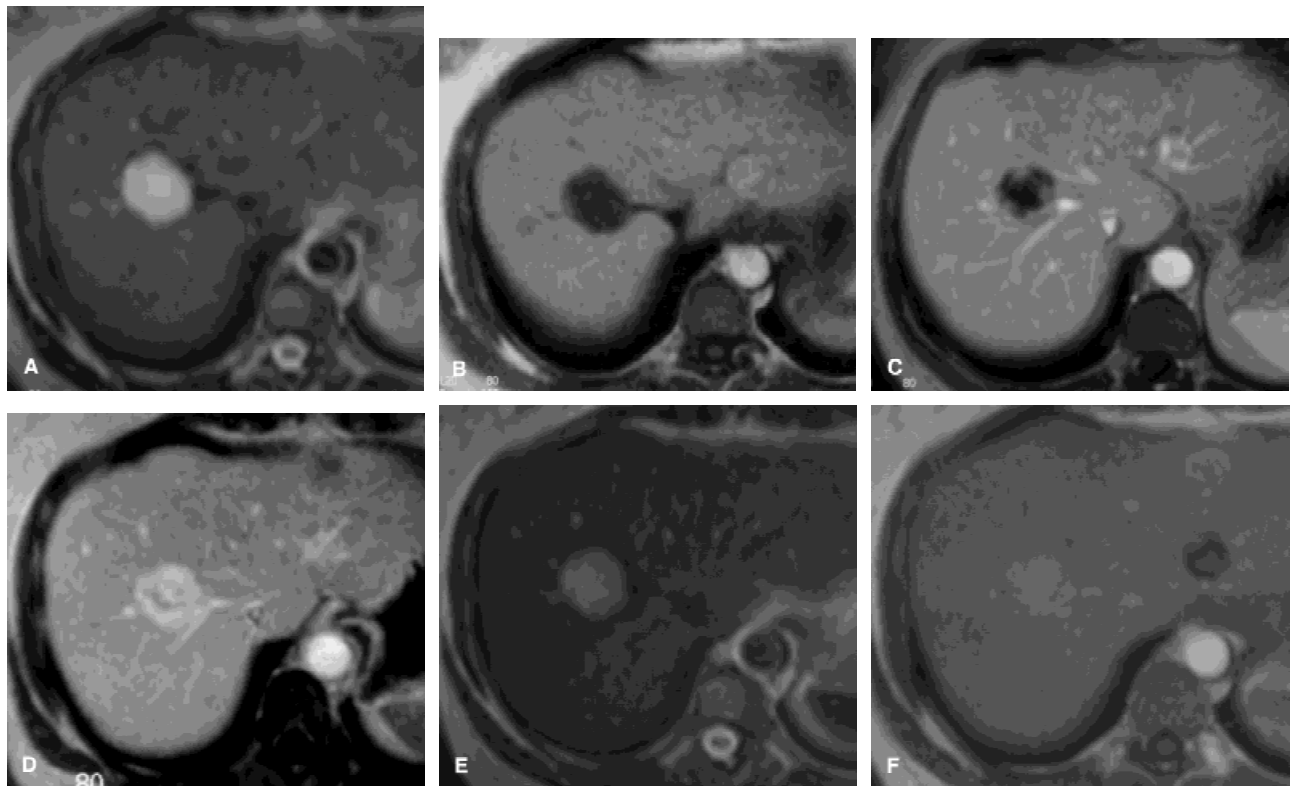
Hemangioma in a 53-year-old woman. a: SE transverse T2-weighted image shows a round hyperintense lesion in the right lobe of the liver, which is hypointense on GRE transverse T1 precontrast image (b). During dynamic imaging with bolus administration of Gd-BOPTA (GRE transverse T1-weighted), the lesion shows a globular peripheral enhancement, starting in the arterial phase (c) and becoming homogeneously hyperintense on the distribution phase (d). e: SE transverse T2-weighted images 1 hour after administration of Endorem. Homogeneous signal drop is observed throughout the liver and the lesion, which persists slightly hyperintense to the surrounding liver parenchyma. f: GRE transverse T1-weighted image 1 hour after administration of Endorem. The hemangioma appears slightly hyperintense.
